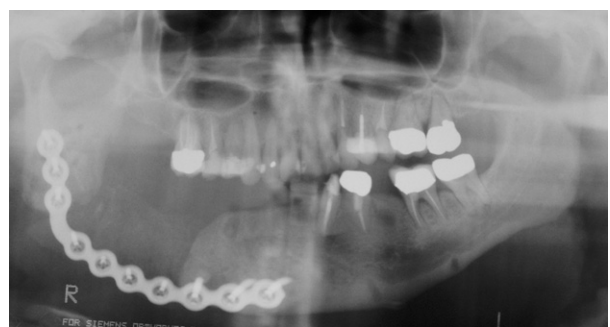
Case 4. Panoramic radiograph showing the bone defect reconstructed with an iliac crest bone graft after failure of rhBMP, bone marrow aspirate, and allogenic cancellous bone graft.
